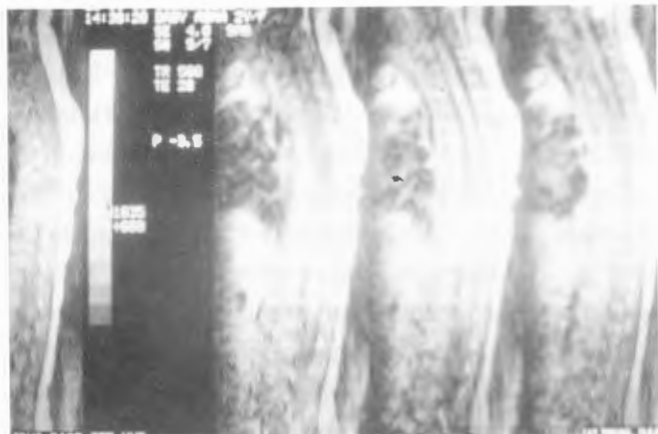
MRI spine in a 2-year-old girl with dorsal midline sinus going upto spinal cord. The girl underwent excision of the sinus tract. The urinary tract was normal at that time.
